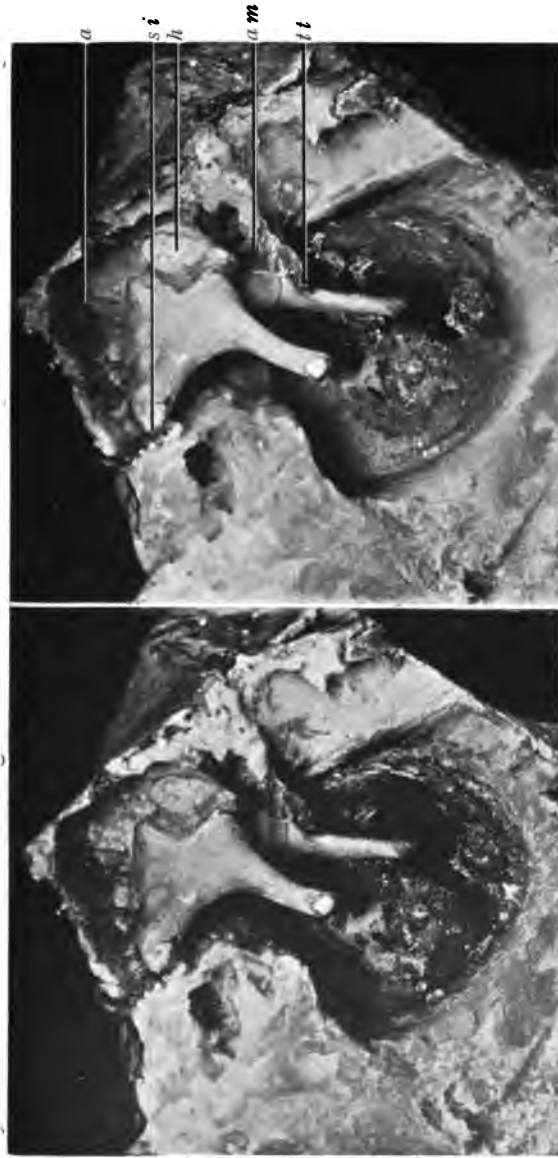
INNER WALL OF TYMPANUM, ETC.: VIEWED FROM THE OUTER ASPECT. X 24.
